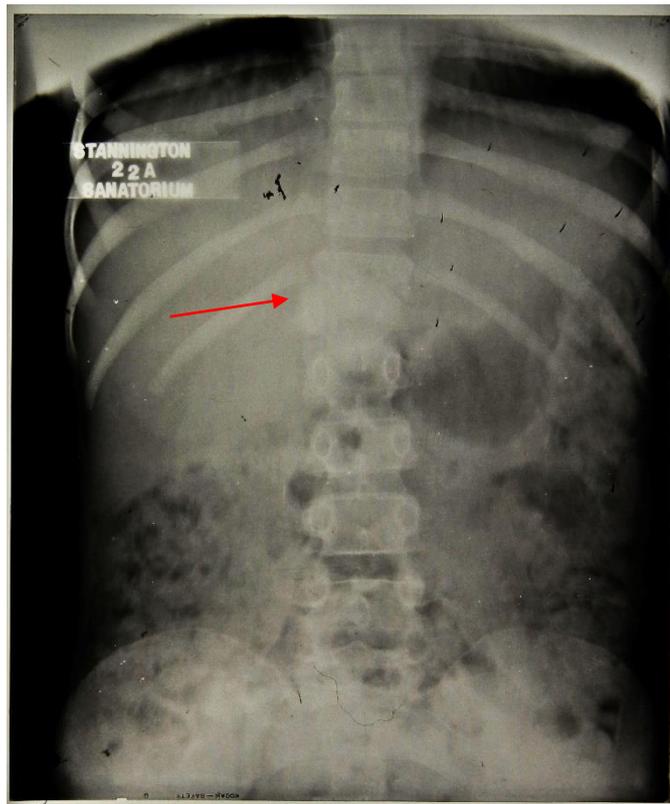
Patient 87/62 radiograph report 5th January 1937: 'T12 and L1 destroyed. No abscess seen. Some lateral slip'. This image presents the problems in identifying specific detail of the pathology from an AP projection of the spine, the lesion is highlighted by the arrow (HOSP/STAN/7/1/2/487_16)
